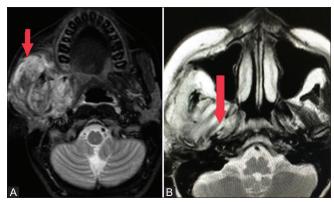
(A and B): (A) MRI (STIR axial section) shows oedematous right masseter muscle (red arrow). (B) MRI (T2 axial section) shows oedematous right pterygoid muscle (red arrow)
